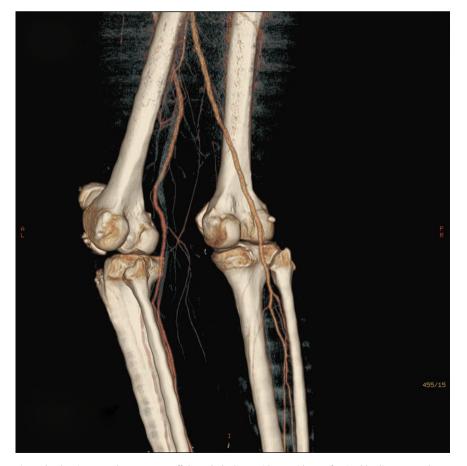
Computed tomography angiography showing smooth contrast runoff through the knee without evidence of active bleeding or pseudoaneurysm involving the left popliteal artery.
